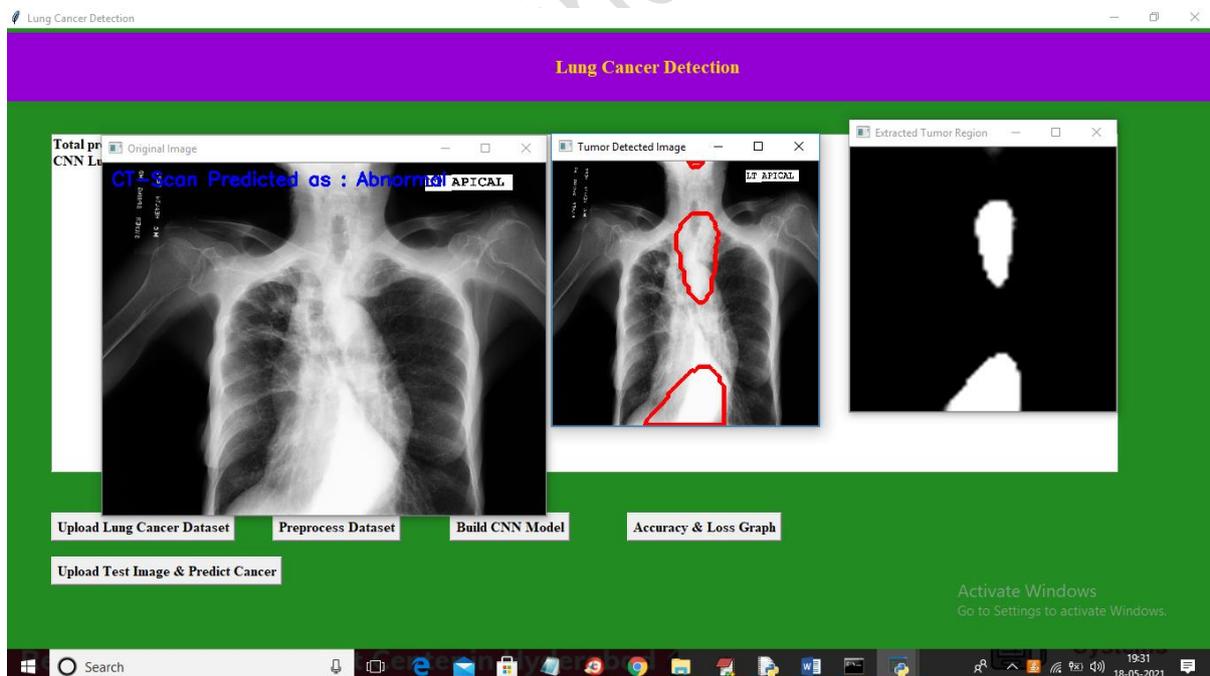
In above screen in first image in blue colour text we can see predicted result as CT-SCAN contains abnormality and in second image we are detecting places were abnormality detected and in third image we extracted all abnormality patches from original image and then displaying. Now test other image
